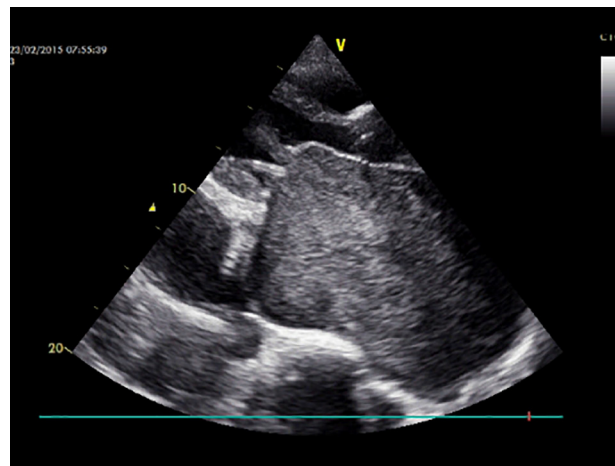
Transthoracic echocardiogram (parasternal long-axis view) shows rheumatic mitral leaflets, gross pericardial effusion, dense left atrial spontaneous echo contrast, and thickened pericardium.
